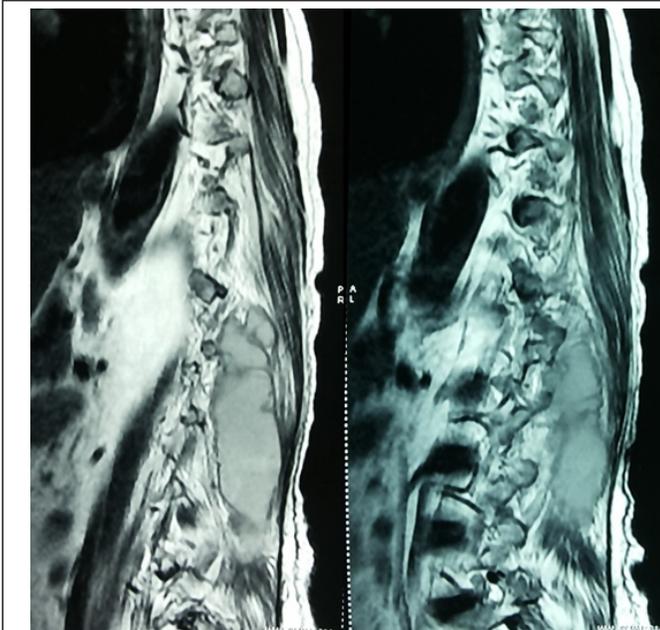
T2-weighted sagittal MRI image of thoracolumbar spine showing a loculated hyperintense collection in left posterior paraspinal muscles measuring 11.7x2.9 cm extending from T12 to L4.
